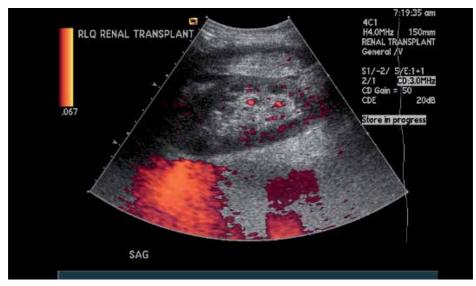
Doppler ultrasound demonstrates global hypoperfusion of the transplanted kidney consistent with renal artery thrombosis on postoperative day 1.
